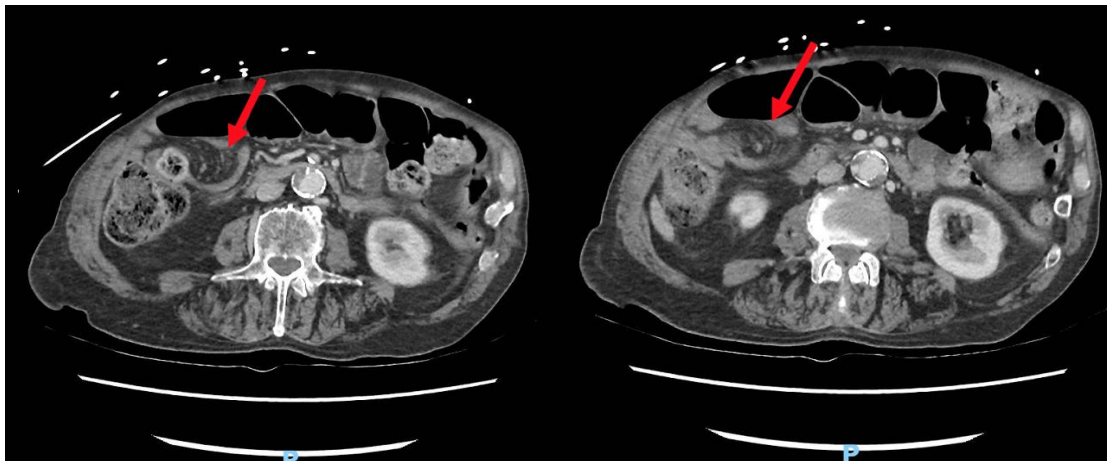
Axial computed tomography images on presentation with arrows pointing to whirl sign
